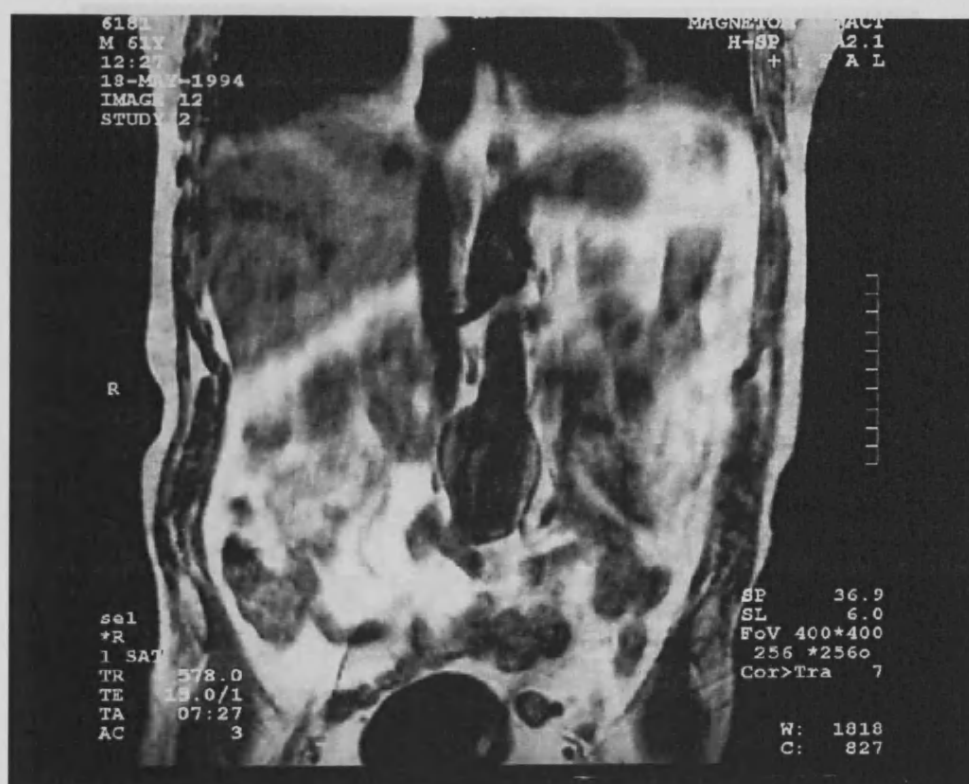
An image of an abdominal aortic aneurysm obtained using conventional MRI (spin echo sequence).
